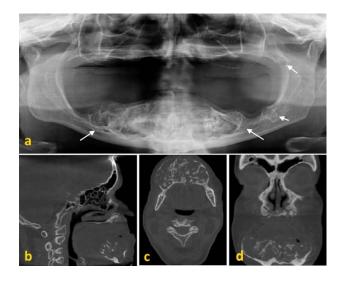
(a) The panoramic radiography of OF. The CBCT image of OF: (b) sagittal, (c) axial, and (d) coronal section showed multilocular lesion in the anterior mandible, a unilocular lesion at the left posterior mandible, and multilocular lesion on the anterior maxilla.
